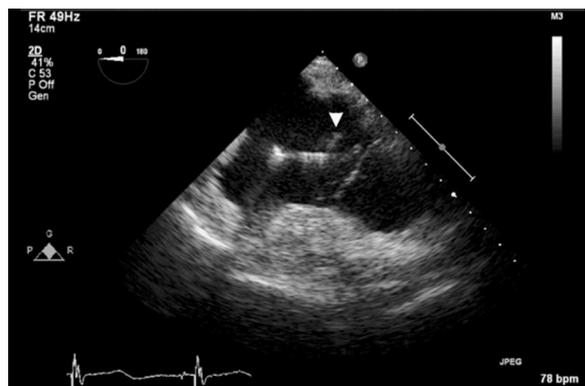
Transesophageal echocardiogram of the pacemaker lead. An apparently small vegetation (arrowhead) was visible on the ventricular portion of the lead.
